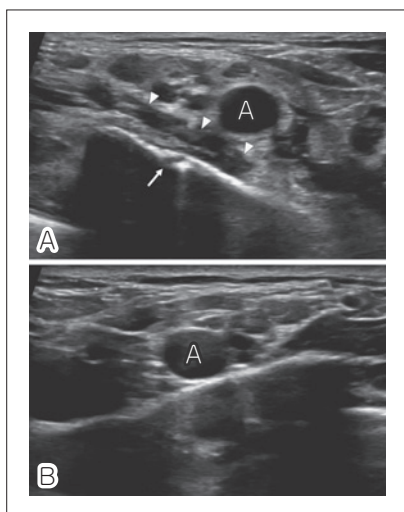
Ultrasound image of the right first rib (A) showing the fracture line (arrow) and the surrounding hematoma (arrowheads). The distance between the first rib and the subclavian artery was significantly increased compared to the healthy side. Normal ultrasound image of the left first rib (B) showing the subclavian artery just above the first rib. A, subclavian artery.
